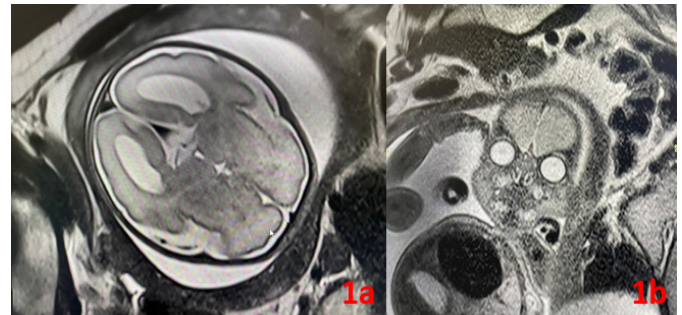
Fetal cranial MRI demonstrating corpus callosum dysgenesis
